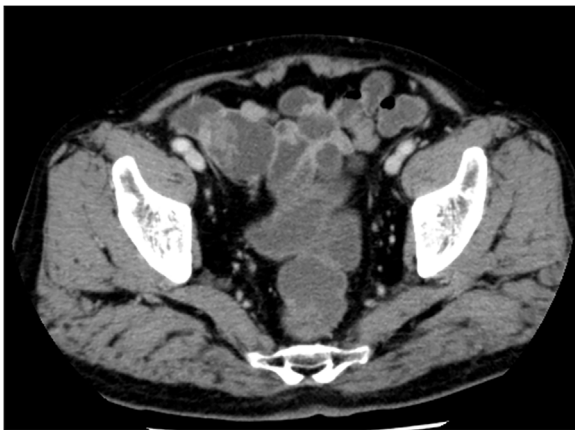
Abdominal CT on admission. Abdominal CT shows high-density bowel fluid in the distal side of the ileum. There is no ascites, and no other suspicious bleeding points are seen.
